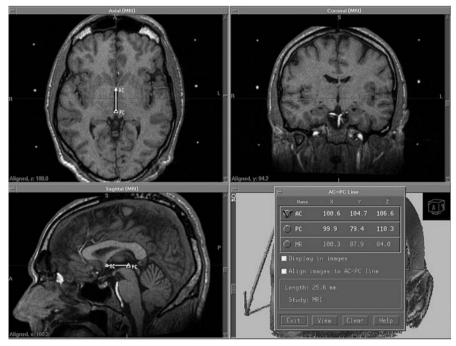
Surgiplan (Elekta Instrument) software, showing stereotactic MRI data in three orthogonal planes after alignment of the AC-PC plane in the horizontal position. The coordinates x, y and z of any point can be shown in the display on the screen. In this figure the coordinates of AC and PC are given
